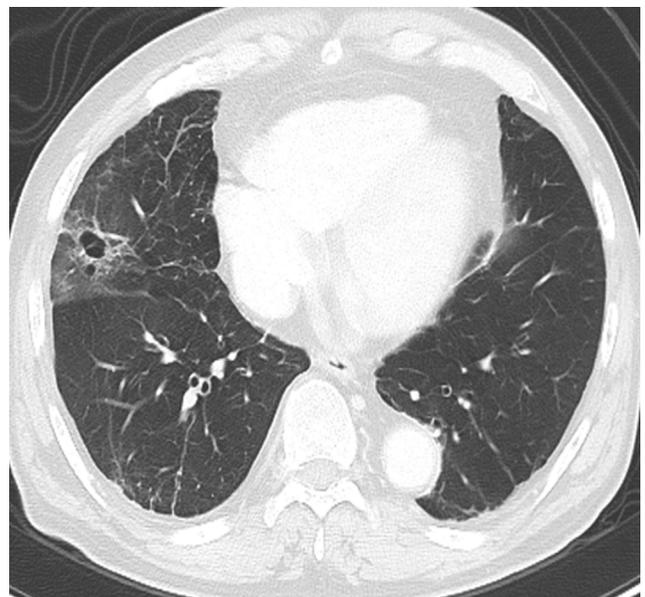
A CT scan after 6 weeks of osimertinib treatment showed that the lesion had shrunk.
